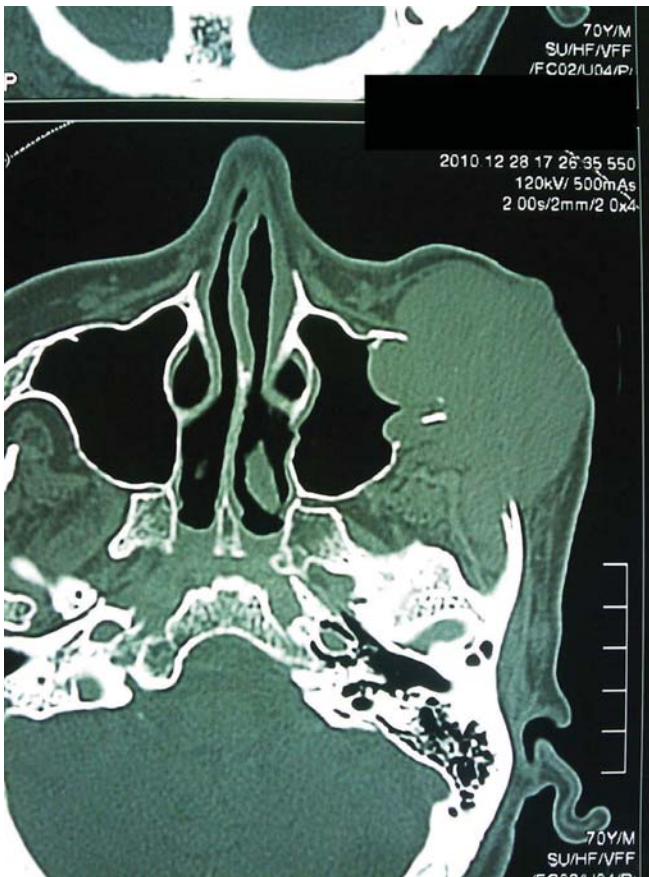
Facial CT scan shows soft-tissue-density mass in the left zygomatic region.
